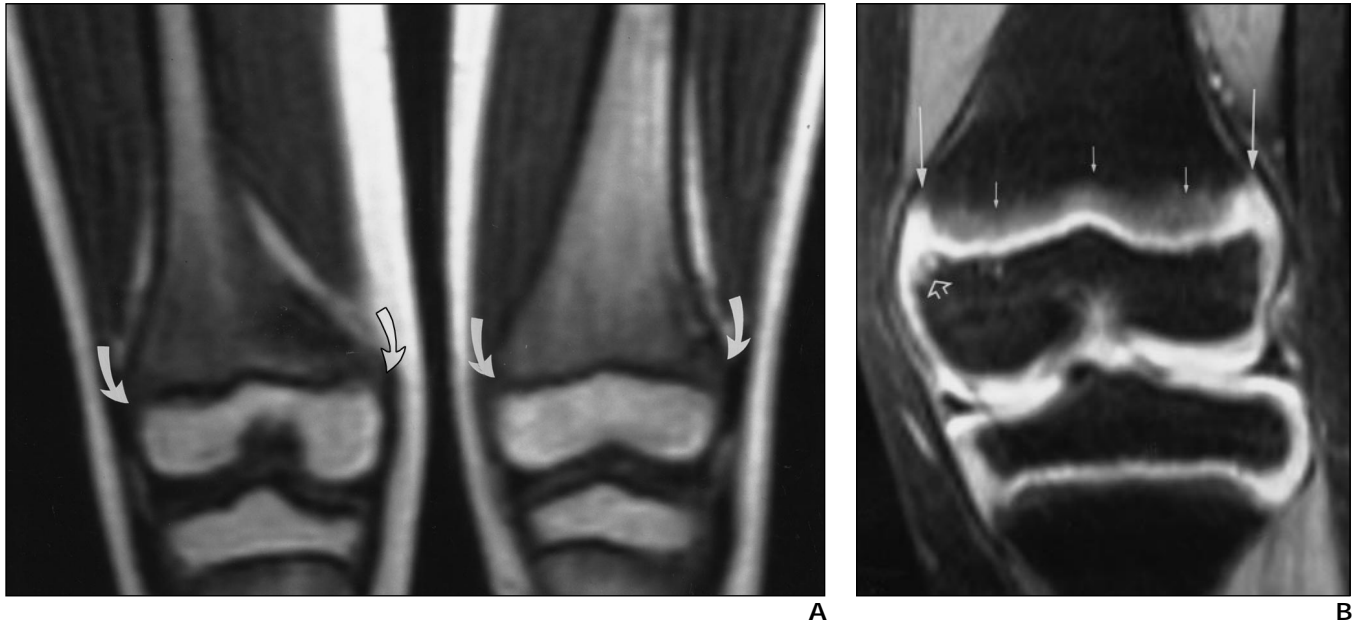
10-year-old girl who underwent chelation therapy for 7 years 5 months. Her height was 6 cm below third percentile at time of MR imaging. A, Coronal spin-echo T1-weighted image (TR/TE, 450/15) of distal femurs shows widening of intermediate-signal-intensity physis at both medial and lateral margins bilaterally (arrows). B, Fat-saturated proton density-weighted MR image (2000/20) of left distal femur shows increase in signal intensity of juxtaphyseal metaphysis, blurring of physal-metaphyseal junction (short arrows), and widening of physis at both medial and lateral margins (long arrows). Slightly irregular outline is observed at medial corner of epiphysis facing physis (open arrow).
